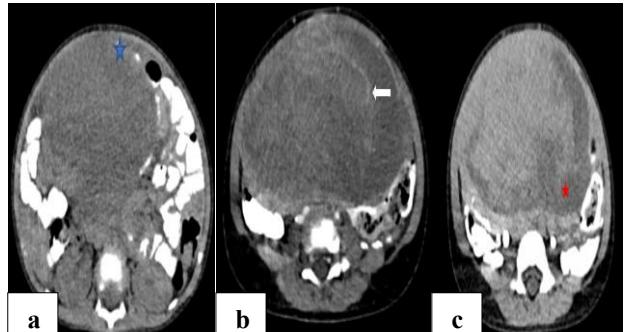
Computed tomography of the abdomen (axial sections) shows (a) hypodense mass in the intraperitoneal cavity on a non-contrast scan (blue asterisk), (b) on the venous phase, feeding vessels are seen (white arrow) arising from the abdominal wall, and (c) on the delayed phase, enhancement is seen with non-enhancing necrotic areas (red asterisk).
